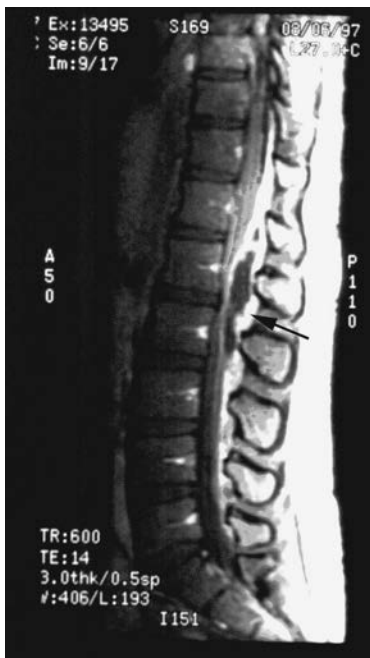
Sagittal T1-weighted magnetic resonance image of the spine after intravenous administration of gadolinium. There is a large gadolinium-enhanced mass (*arrow*) in the posterior epidural space extending from T9 to L3. The area of low signal density within the abscess represents a poorly perfused area of liquefaction. (From Rathmell JP, Garahan MB, Alsofrom GF: Epidural abscess following epidural analgesia. *Reg Anesth Pain Med* 25[1]:79–82, 2000.)
